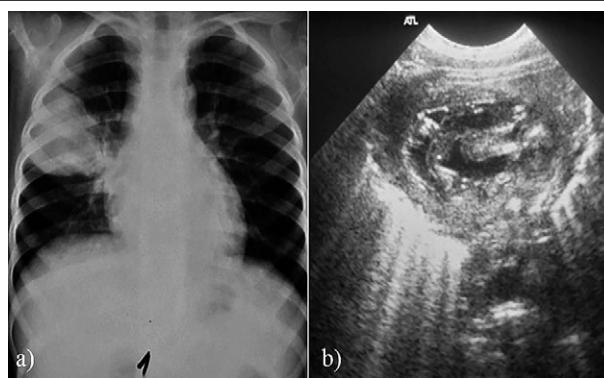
Hydatid cyst of the right lung. A 6-year-old boy presents with dry cough and mild fever without chest pain, dyspnoea or weight loss: (a) anteroposterior view of chest x-ray shows a well-defined round radio-opacity in the right upper zone; (b) transthoracic ultrasound demonstrates the coiled floating membrane within a fluid collection - pathognomonic features of Gharbi's classification type IV hydatid cyst.
